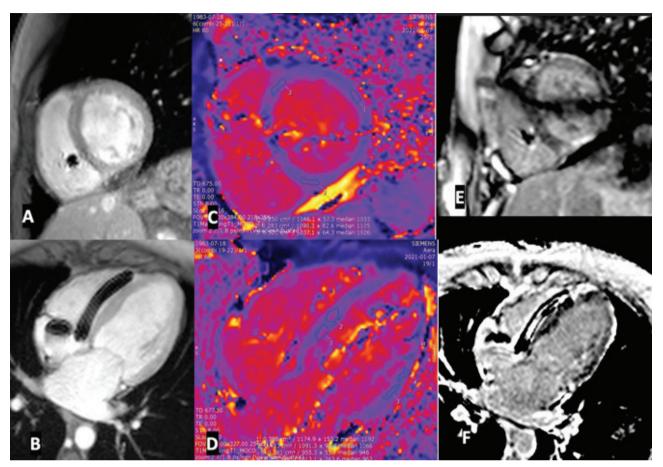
Female 37 years old with LMNA-related dilated cardiomyopathy and implanted pacemaker. Short Axis (A) and 4Chamber(B) Cine MRI (SSFP) show LV dilatation (LV Ejection Fraction 37%,RV EF 32%). T1 mapping SA and 4CH (C and D) visualizes increased T1 values indicative of fibrosis mainly at the IVS. SA and 4CH LGE (E and F) show areas of enhancement with a nonischemic pattern.
